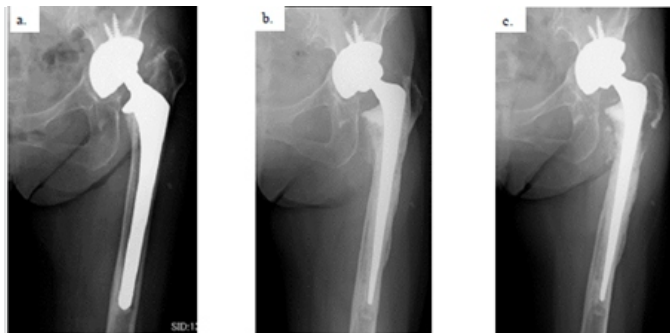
Radiographic findings. (a) Loosening and subsidence of the femoral stem with a bone defect of the proximal femur are observed before revision in 2011. (b) There is no osteolytic image around the stem at 3 years after surgery in 2014. (c) Osteolytic image is observed on the distal exterior (zone 1) of the greater trochanter and lesser trochanter (zone 7) at 4 years post-operative in 2015.
